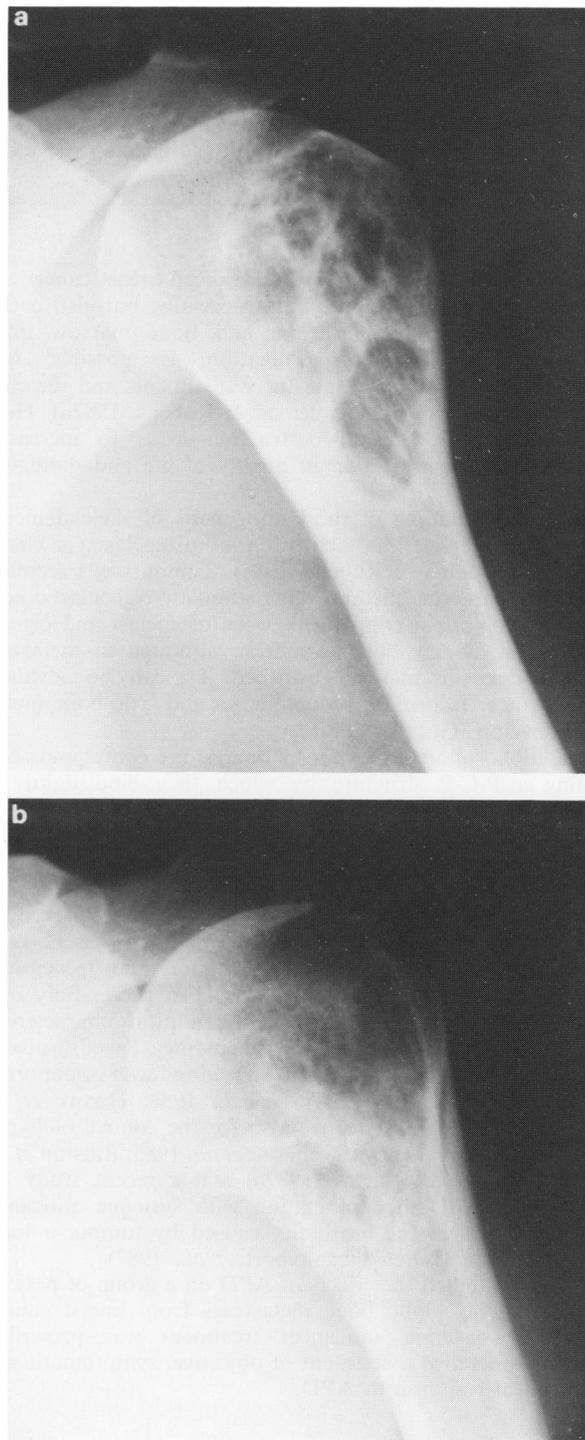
Plain radiographs of the left upper humerus (a) before and (b) 6 months after treatment with APD. The lytic lesion has undergone sclerosis.
